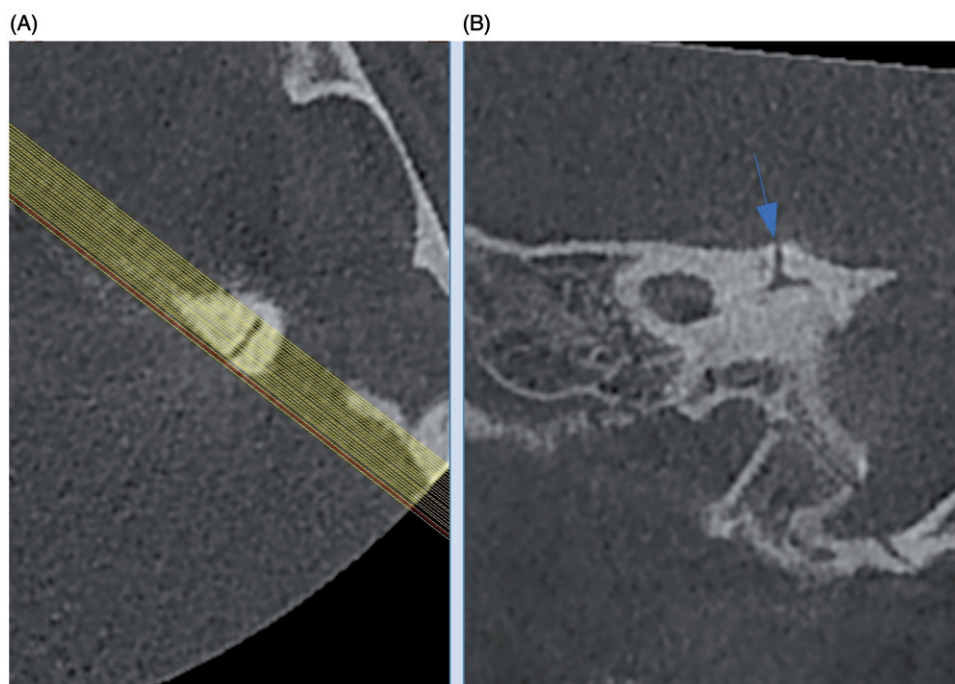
Cone beam computed tomography images. (A) Stenvers plane. Angle of reformation showed on axial CBCT image. (B) Normal features are seen on axial reformatted image.
